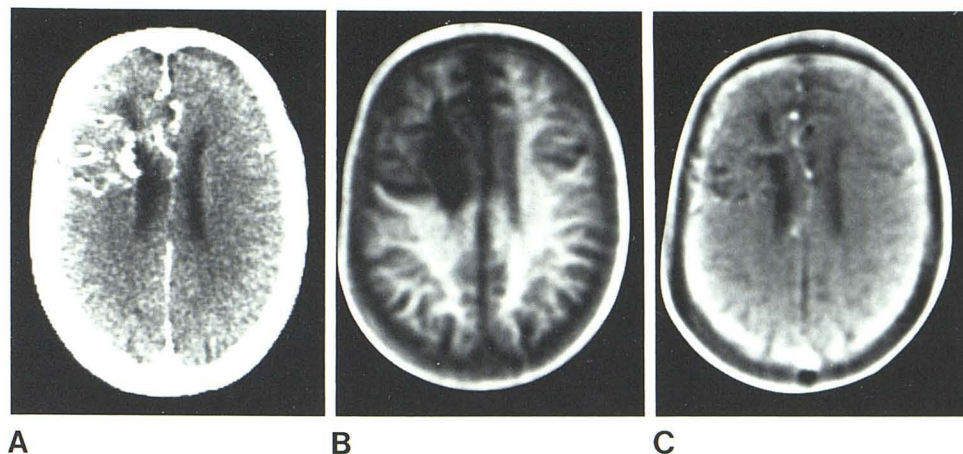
Tuberculous meningitis. A, CT. B, $IR_{1400/400}$. Areas of infarction demonstrated with both scans. In addition, cerebral white matter appears to "merge" with bone marrow.
